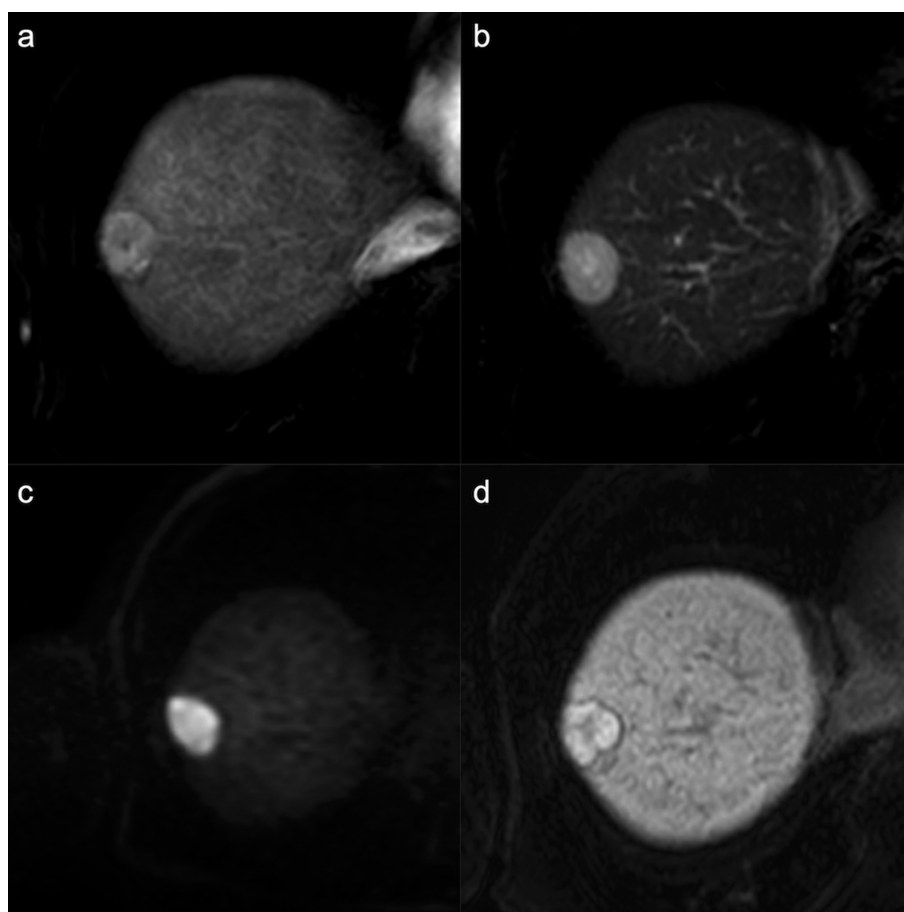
MR images from a 76-year-old male of alcohol-related hepatocellular carcinoma with β -catenin mutation. The nodule in the segment VIII shows hyperenhancement on the arterial phase (a), hyperintensity on T2 weighted imaging (b) and diffusion weighted imaging (c), and hyperintensity on the hepatobiliary phase (d). The nodule includes the tumor capsule (a and d).
